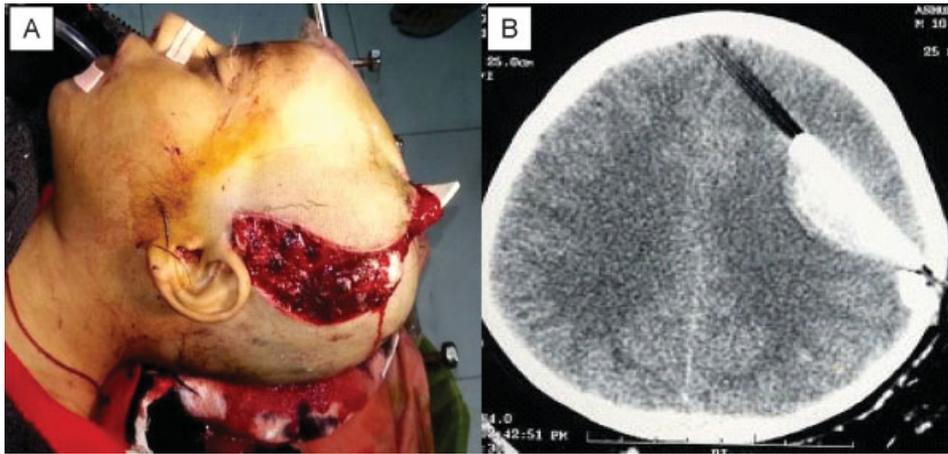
A 10-year-old boy with accidental injury by plastic pipe. (A) The patient's photograph with plastic pipe inside brain. (B) Noncontrast CT scan head with foreign body in situ.
